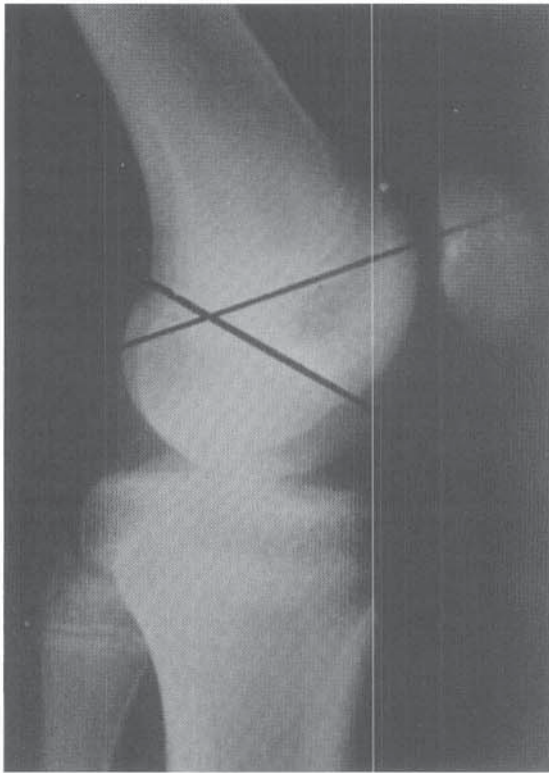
Normal resting position of the patella as seen on a lateral radiograph of the knee obtained with the knee in 30 degrees of flexion. Note that the patella is between the anterior projections of the intercondylar notch line and the metaphyseal plate line (central part of the physis). (From Hughston JC: Subluxation of the patella. *J Bone Joint Surg* 1968;50-A:1013.)
